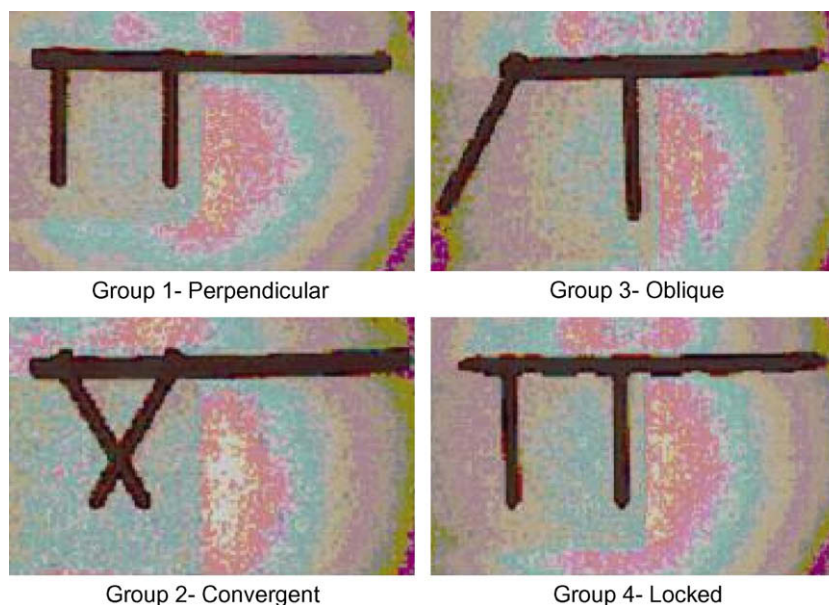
Radiographic depictions of the screw configurations tested in synthetic bone.
